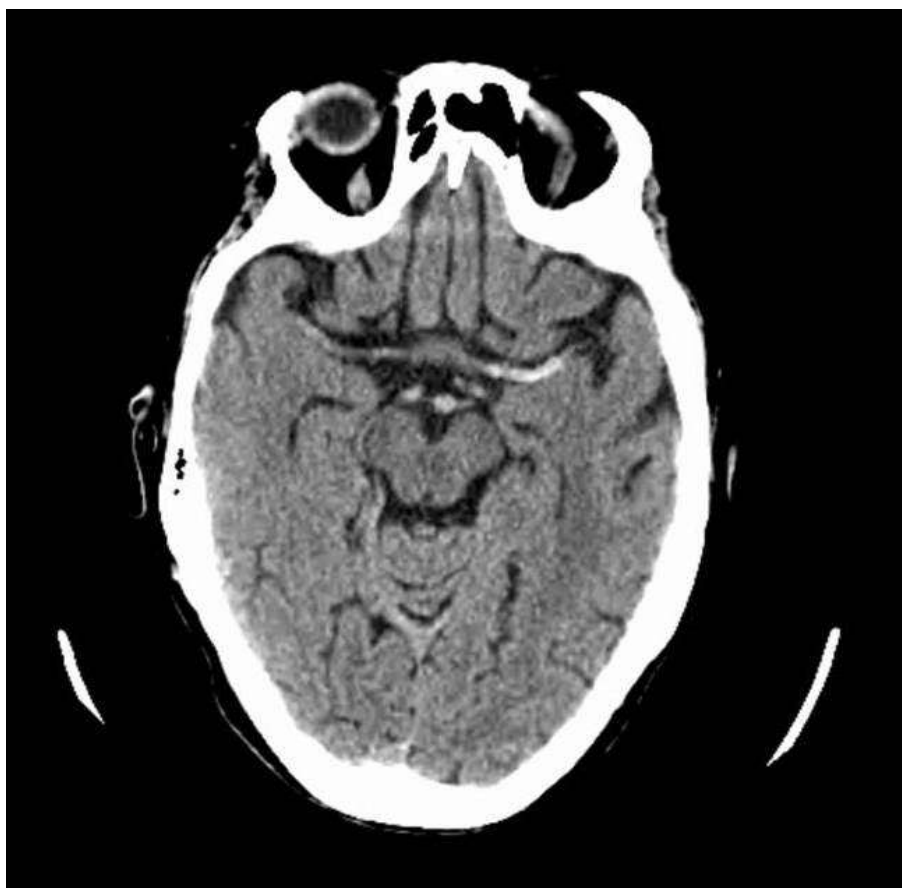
Brain CT-scan: Spontaneous hyperdensity in the M1 segment of the left middle cerebral artery.
